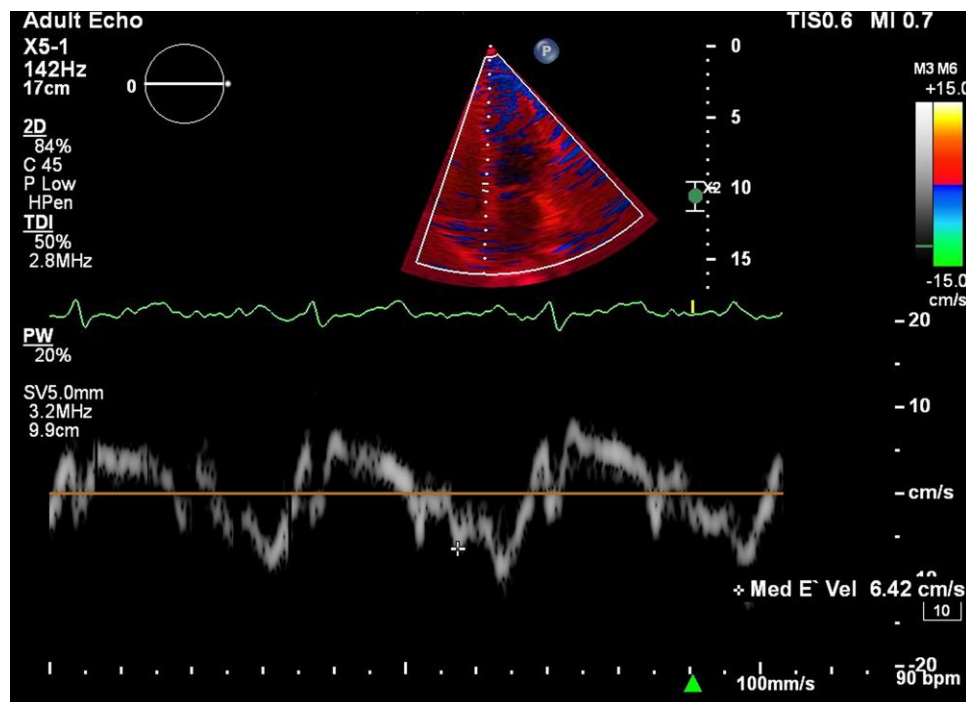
Exploring diastolic function: Tissue Doppler echo in four-chamber view reveals the septal E' velocity, providing valuable insights into the heart's relaxation phase. E' is 6.42 cm/s in this patient.
